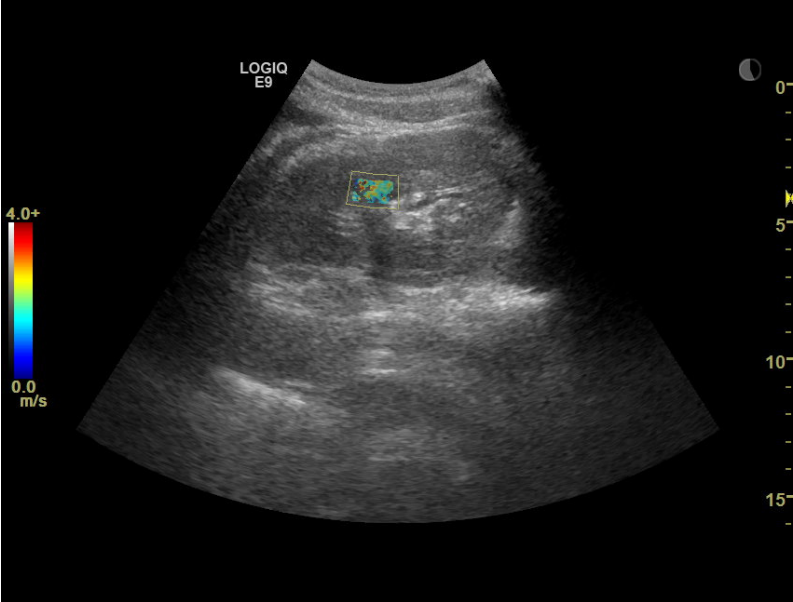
Shear wave speed measured with a 2D SWE.GE system on a Logiq E9 - General Electric ultrasound machine
